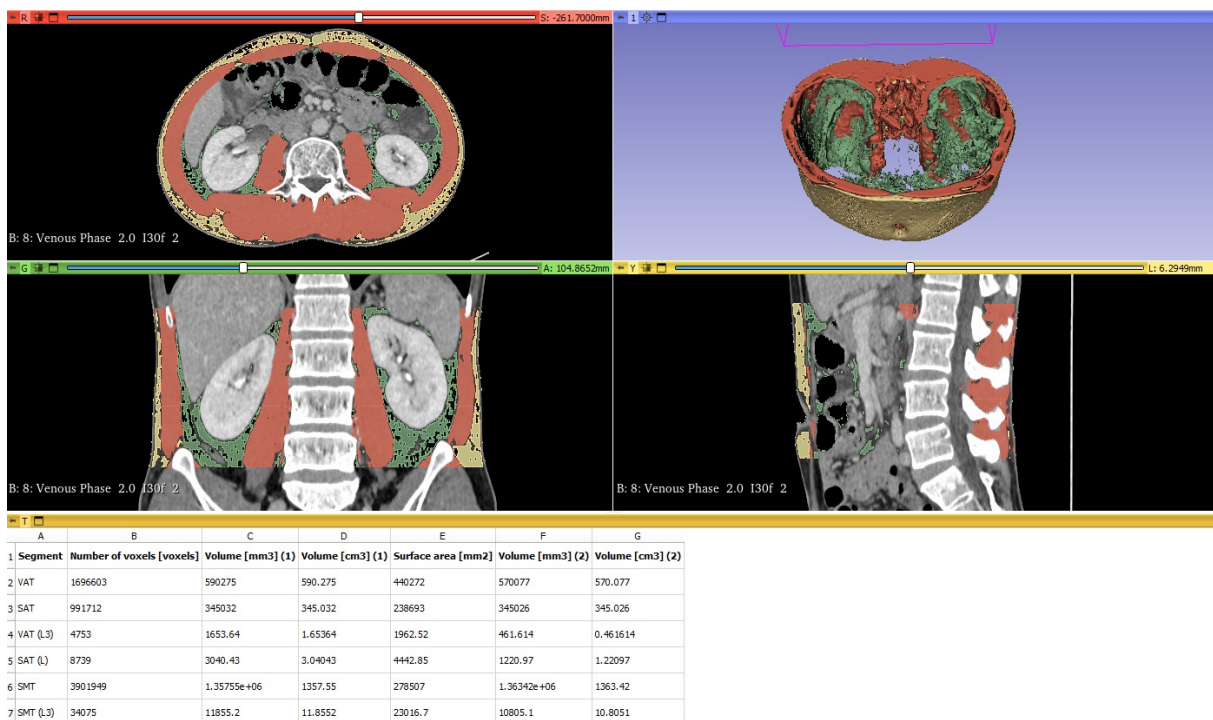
Example of abdominal computed tomography for body composition analysis (upper left: axial plane, lower left: coronal plane, lower right: sagittal plane, upper right: 3D model, bottom: measured variables in 3D and 2D at the level of L3). Visceral adipose tissue (green), subcutaneous adipose tissue (yellow), and skeletal muscle tissue (red) were segmented.
